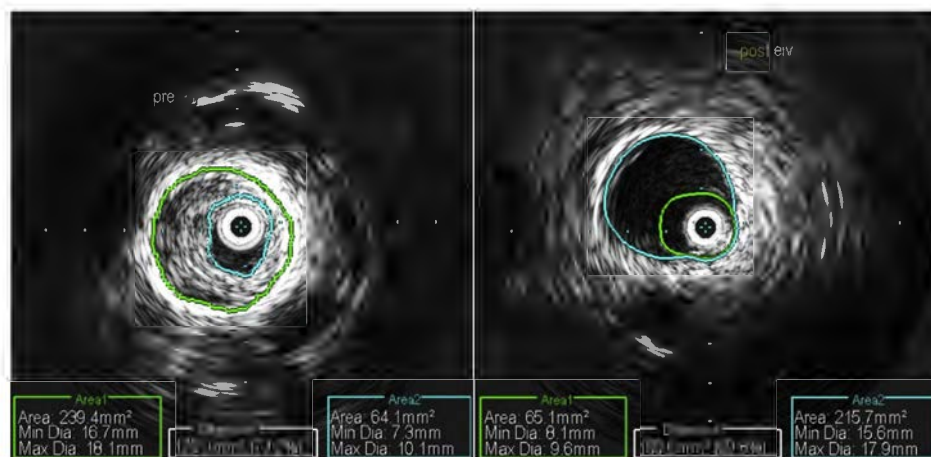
Intravascular ultrasound (IVUS) scans demonstrating the external iliac vein segment of the stent before (Left) and after (Right) laser ablation of in-stent restenosis (ISR).
